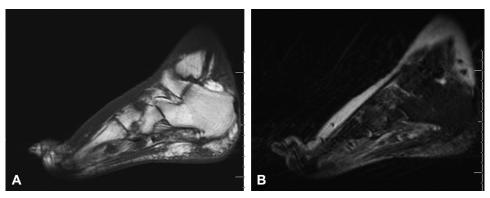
Magnetic resonance imaging of the foot; T1 (A) and T2 Short tau inversion recovery (STIR) (B). Comparative dorsal soft tissue thickening with subcutaneous edema (B) without associated bone marrow edema.
